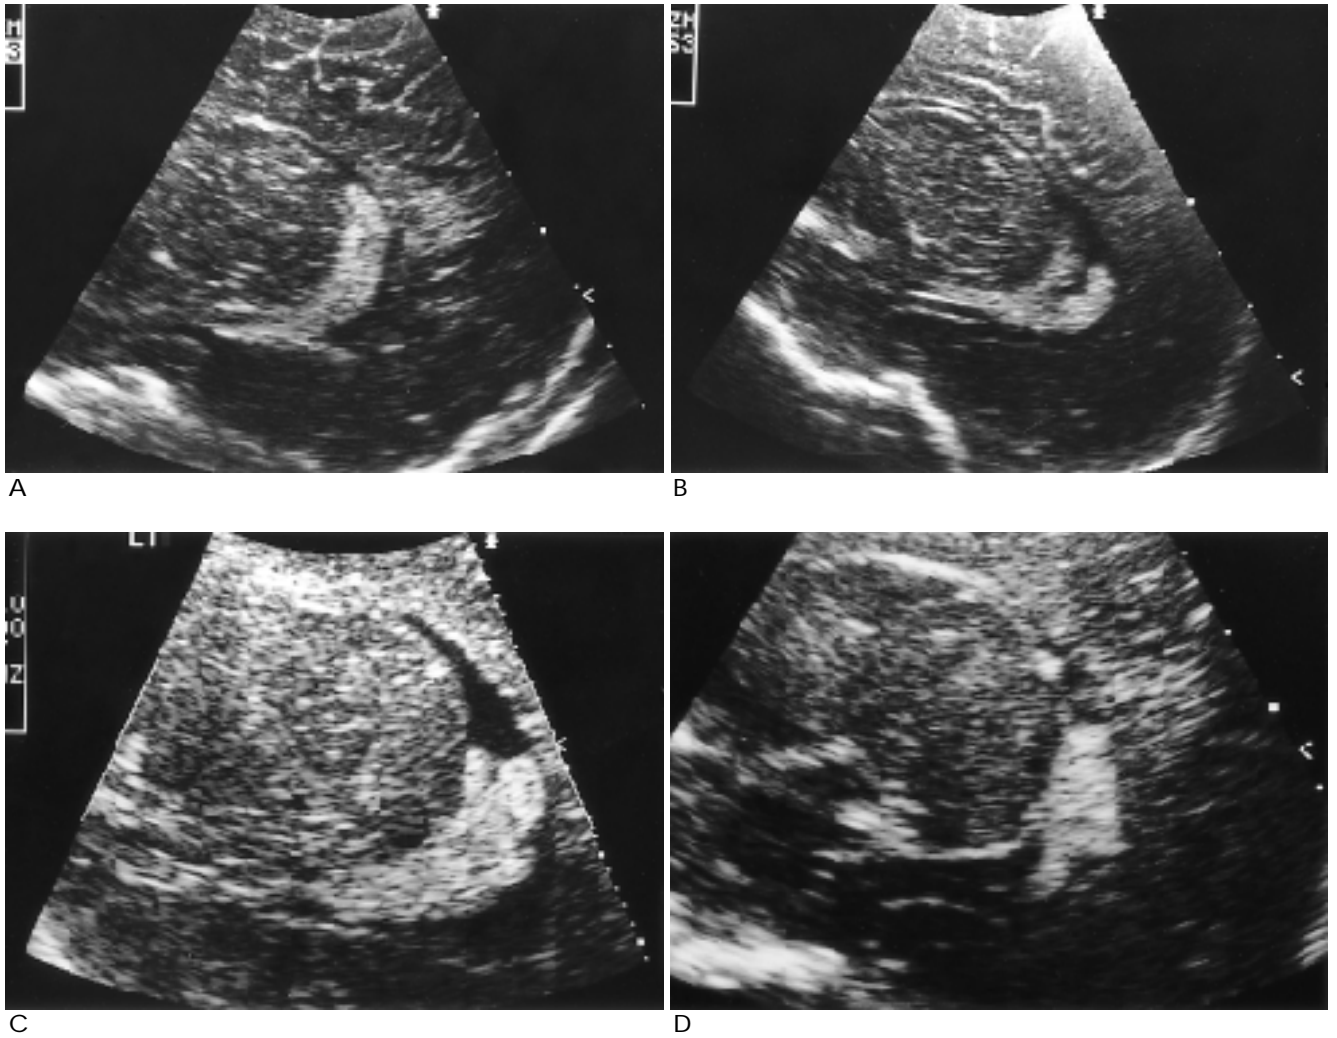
Parasagittal scans of brain sonography in normal full-term infants show crescent shape(A), superior notching(B), dorsal bulging(C) and inferior notching(D) of the glomus.
